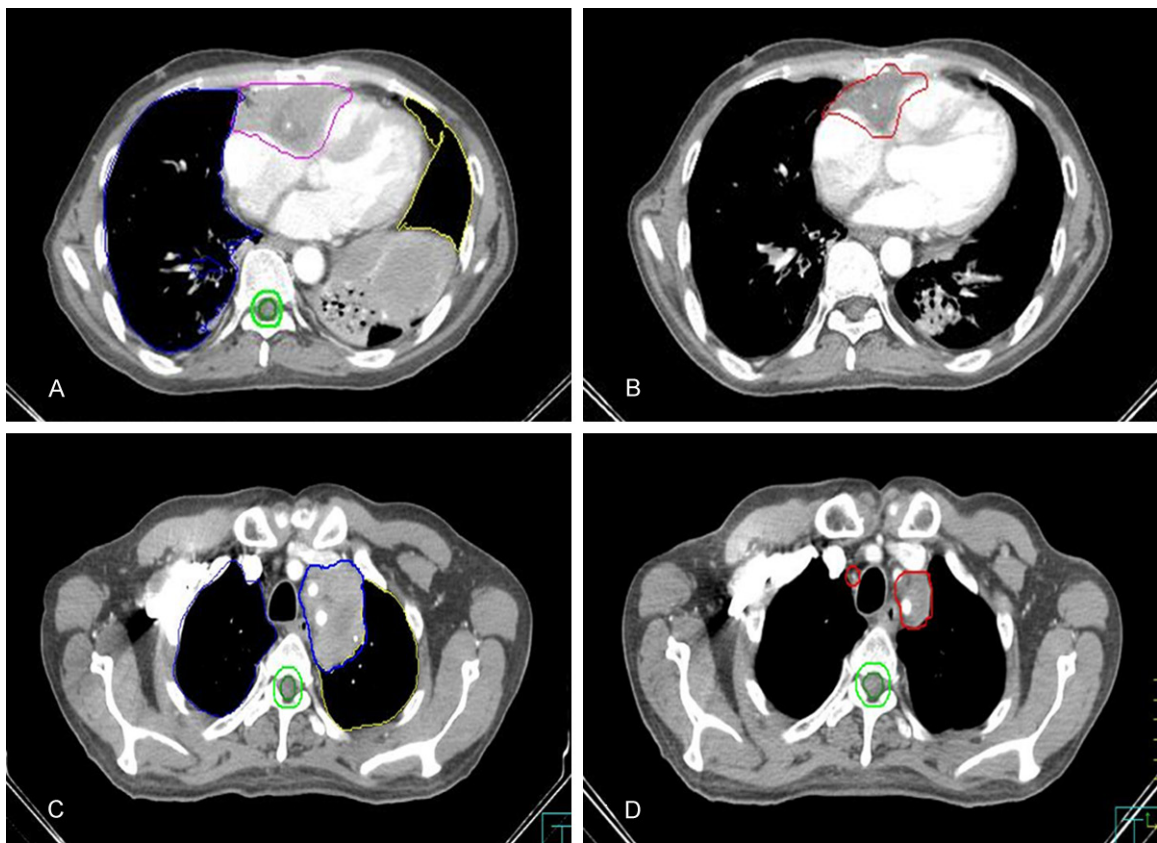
CT imaging. A: Anterior right ventricular tumor before radiotherapy, B: Reduction in the right ventricular tumor after radiotherapy, C: Upper left mediastinal trachea tumor before radiotherapy, D: Significant reduction in the upper left mediastinal trachea tumor after radiotherapy.
